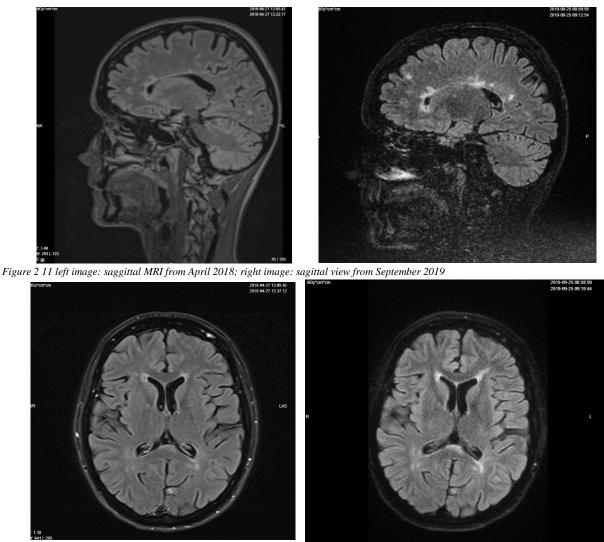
12 left image: axial MRI from April 2018, right image: axial MRI from September 2019
